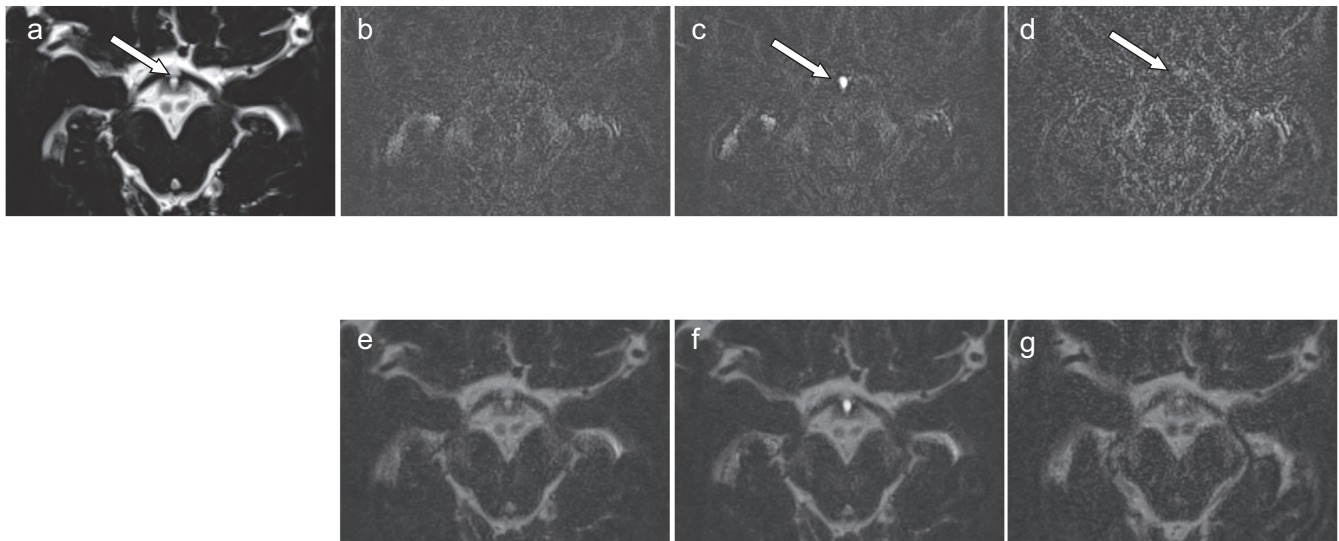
Chronological changes in contrast enhancement in the infundibular recess. The infundibular recess shows hyperintensity on MRC (a, arrow). On HT2-FLAIR, in comparisons with a precontrast image (b), a postcontrast image (c, arrow) shows stronger enhancement of the infundibular recess. A 4-h delayed postcontrast image (d, arrow) demonstrates decreased contrast enhancement of the infundibular recess. We fused an MRC image and each HT2-FLAIR image into one blended image (e, f, and g), on which contrast enhancement on postcontrast HT2-FLAIR (f) corresponds to the hyperintensity of the infundibular recess on MRC. 4-h, 4-hour; HT2-FLAIR, heavily T2-weighted 3D fluid-attenuated inversion recovery; MRC, MR cisternography.
